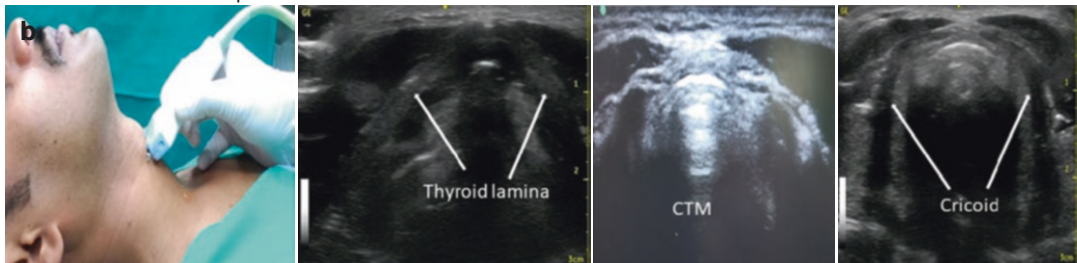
Ultrasonographic identification of cricothyroid membrane (CTM)
